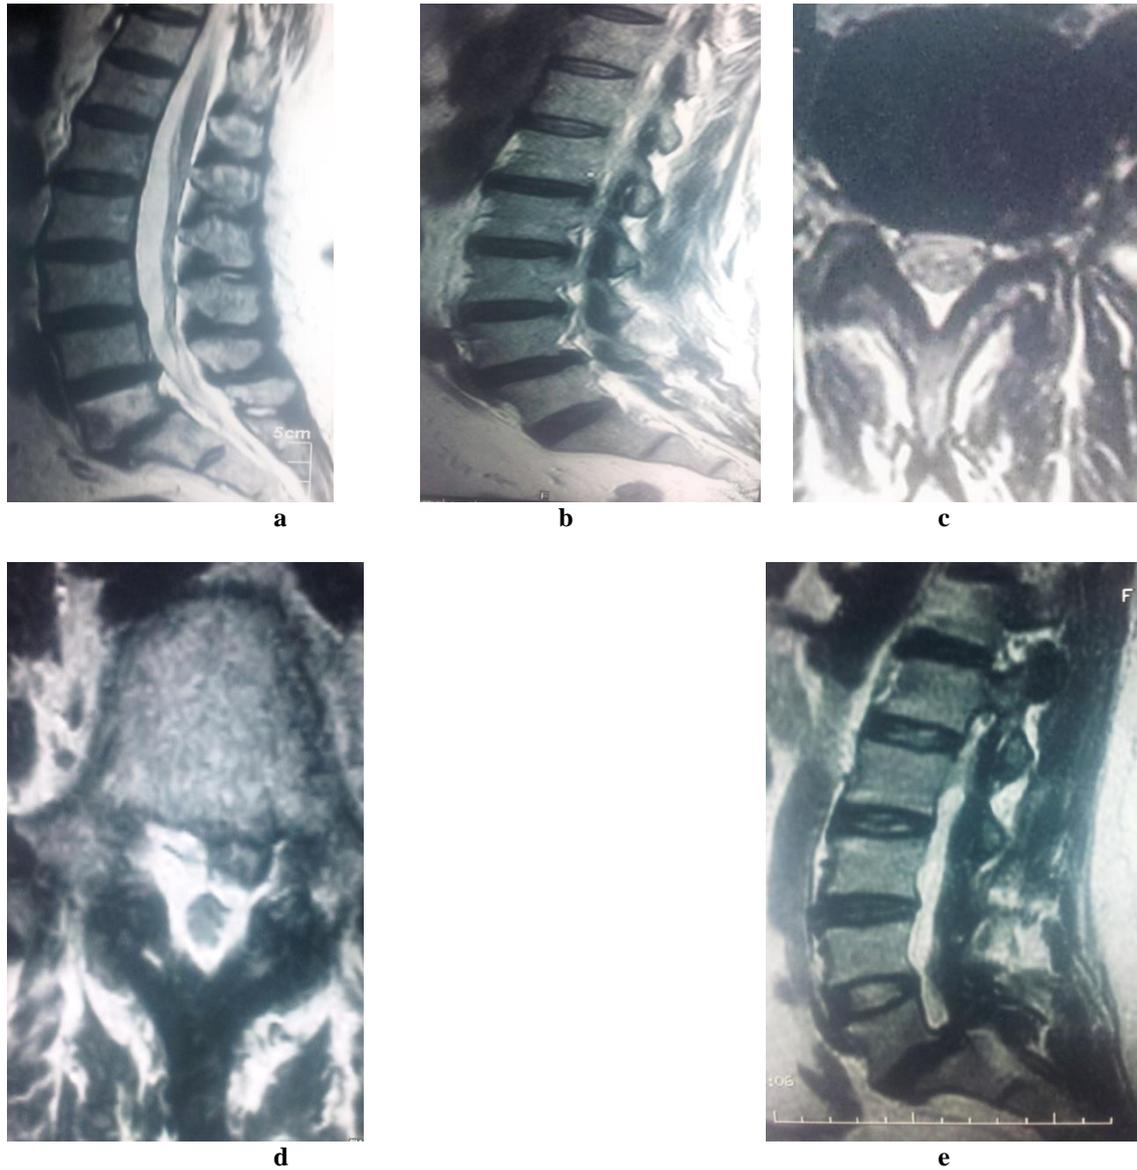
Sample MR images of our patients with lumbar discopathy.
